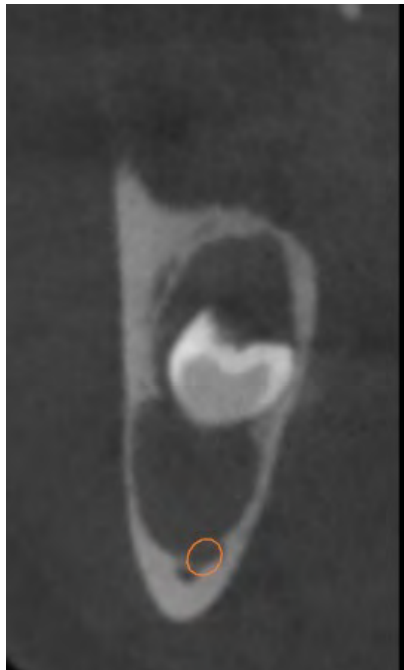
Coronal CBCT image
